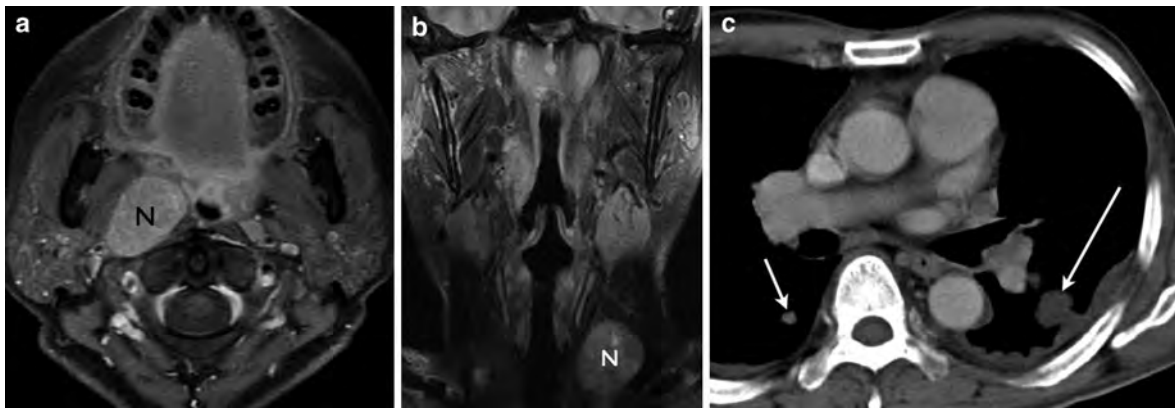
Lymphadenopathy in nasopharyngeal carcinoma. a Axial contrast-enhanced fat-saturated T1-weighted MR image shows an enlarged right lateral retropharyngeal node (N), the first echelon node for nasopharyngeal carcinoma. b Coronal fat-saturated T2-weighted MR image shows an enlarged malignant
